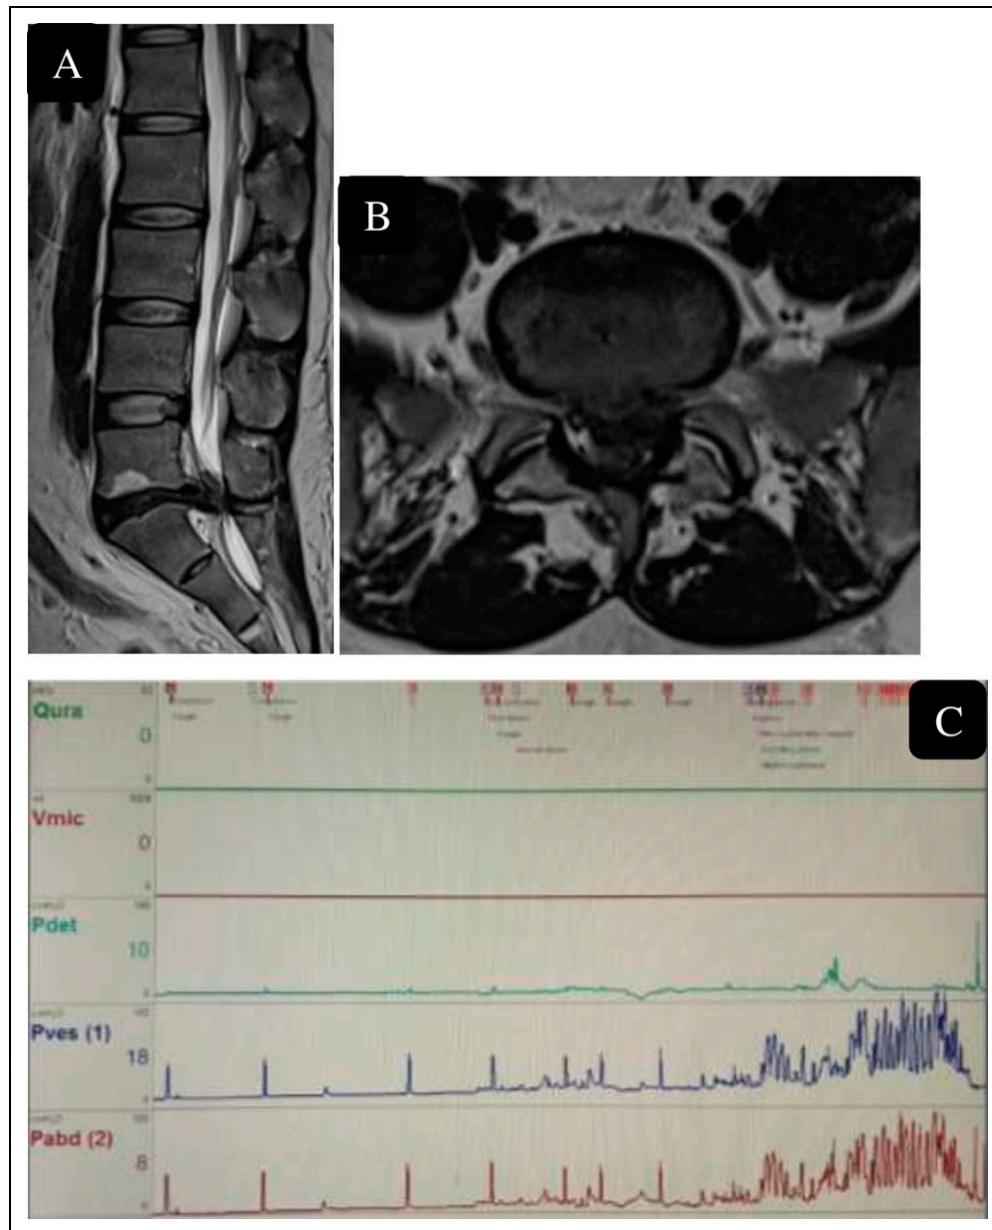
39 year old female with left radiculopathy and urinary retention since 4 days, MRI (A, B) revealed L⁵-S¹ lumbar disc herniation. UDS revealed acontractile bladder with complete loss of detrusor contractions and raised intravesical pressure reflecting the raised intra-abdominal pressure with no flow.
